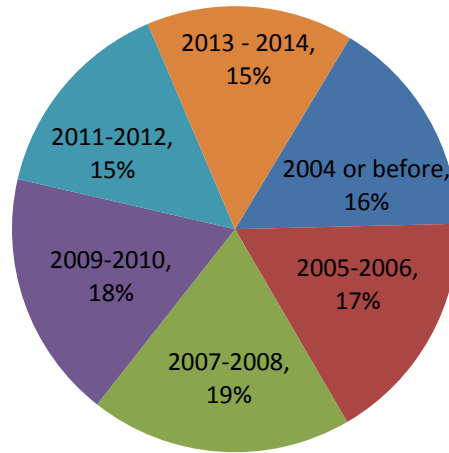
Regional Age of CT Equipment
